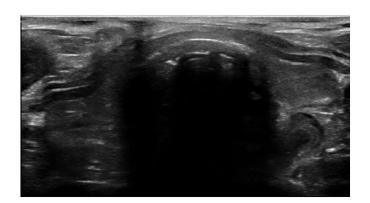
Ultrasound image of an endotracheal intubation.
